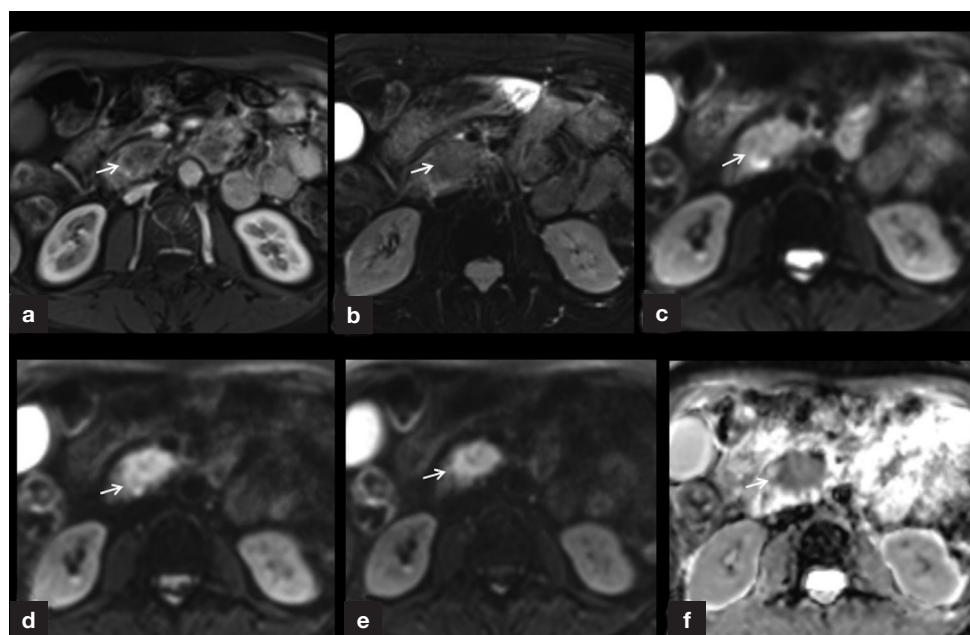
Magnetic resonance imaging of resectable pancreatic adenocarcinoma. a. T1-weighted fat-saturated post-contrast axial image in arterial phase shows a hypointense mass (arrow). b. T2-weighted fat-saturated image shows an intermediate signal lesion. c. Diffusion-weighted imaging with low b-value (b50) shows the lesion, which is mildly hyperintense. d and e. Diffusion-weighted imaging with higher b-values (b400 and b800) show progressive increase in signal in the lesion indicating restriction of diffusion. f. Apparent diffusion coefficient map shows low signal within the lesion signifying restriction of diffusion.
